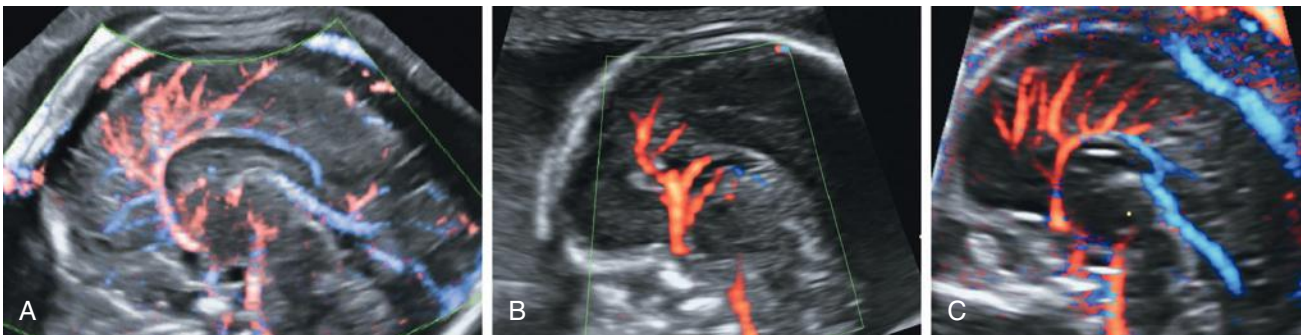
Pericallosal artery. A, In a normal fetus, color Doppler sonography demonstrates the pericallosal artery, which courses adjacent to and highlights the corpus callosum. B, In complete agenesis of the corpus callosum, the loop of the pericallosal artery is lost. The anterior cerebral artery ascends vertically and branches with a tree-like configuration. C, In partial agenesis of the corpus callosum, the pericallosal artery forms an unusually short loop.
